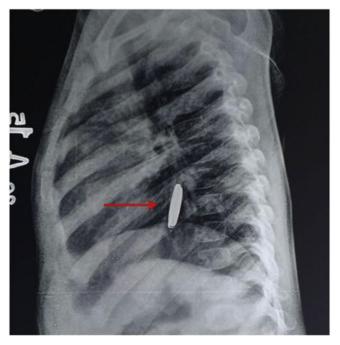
Chest X-ray lateral view showing the "step-off" sign.
